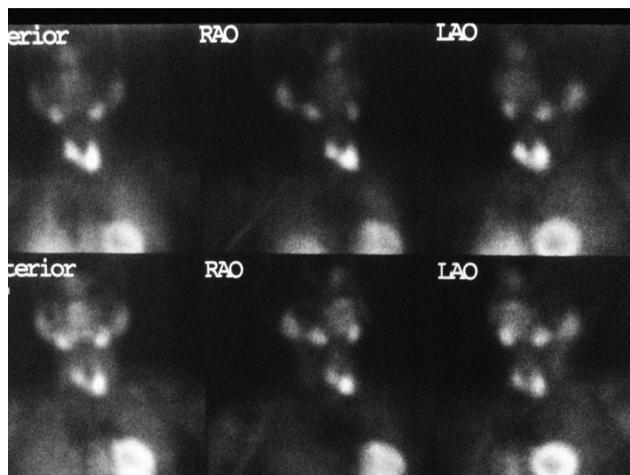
In parathyroid scintigraphy, the late images taken 2 hours after the injection of 25mCiTc-99m MIBI revealed focal sestamibi retention in the zone corresponding to the thyroid left lobe lower pole inferior.
